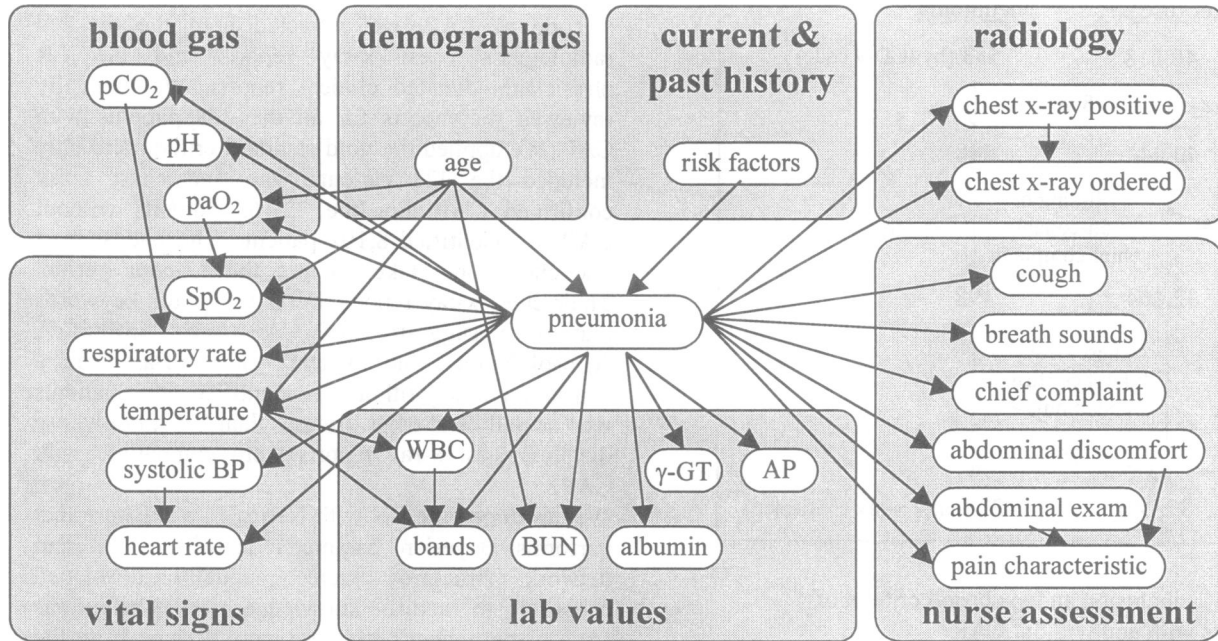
Structure of the Bayesian network. All variables are available in the HELP system during a patient's encounter in the emergency room with the exception of the chest x-ray information ("chest x-ray positive").
